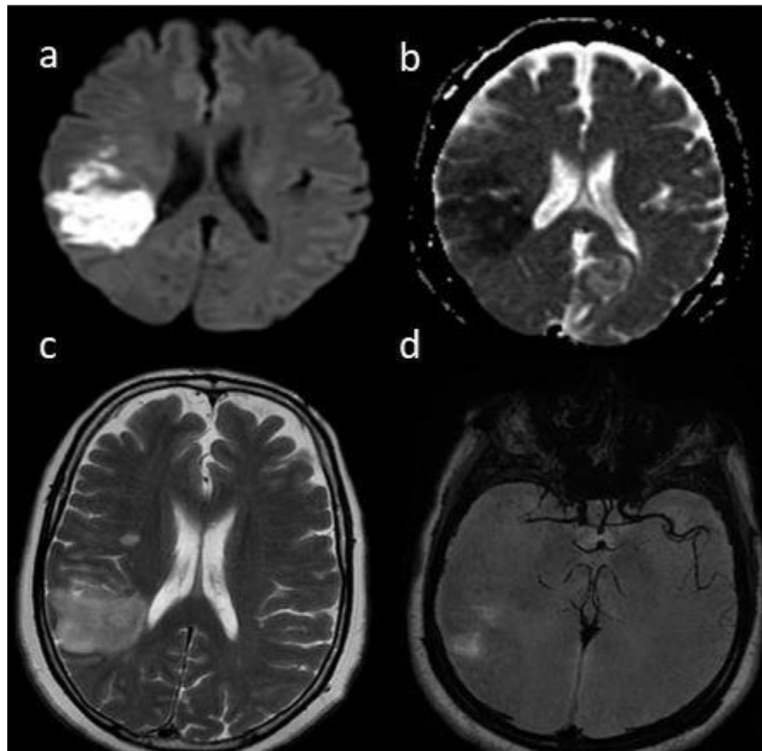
Some of the brain advanced sequences. (a) Diffusion-weighted imaging (DWI), (b) apparent diffusion coefficient (ADC) map, (c) T2 weight image, and (d) dark blood magnetic resonance angiography (MRA).
